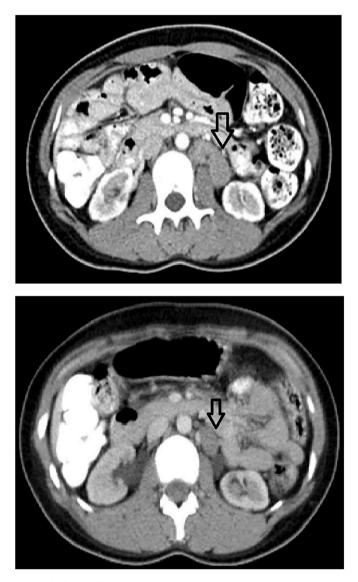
(a) Pre-treatment CT showing paravertebral mass. (b) showing post treatment reduction in size. (c) Pre-treatment PET CT showing paravertebral mass. (d) showing post treatment FDG non avidity and reduction in size.
